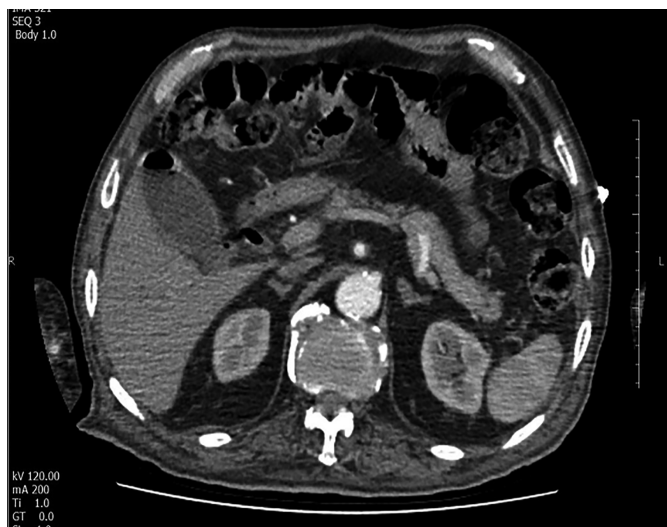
Contrast-enhanced axial CT scan of abdomen. Air is seen in the gallbladder.
